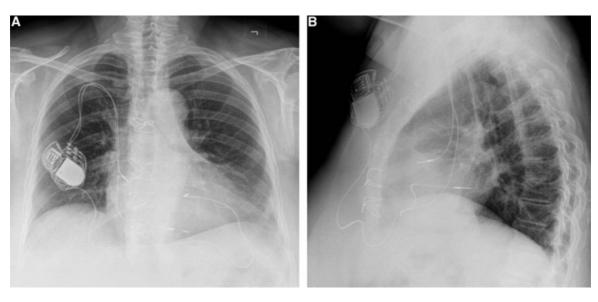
(A) Postoperative chest x-ray from anteroposterior (AP) projection. (B) Postoperative chest x-ray from lateral (LA) projection.
